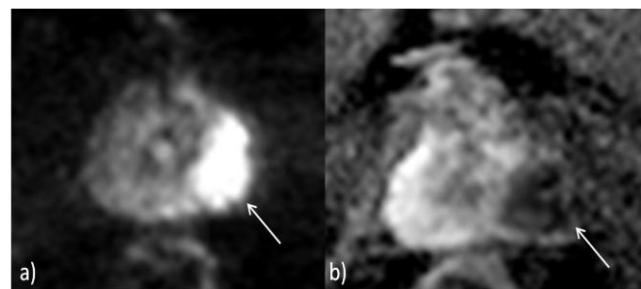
DWI of PCa in the left peripheral zone (white arrow) on a) axial b1400 b) axial ADCmap corresponding to the same tumour in Figure 6. (Source [52]. Reprinted with permission from the publisher).
